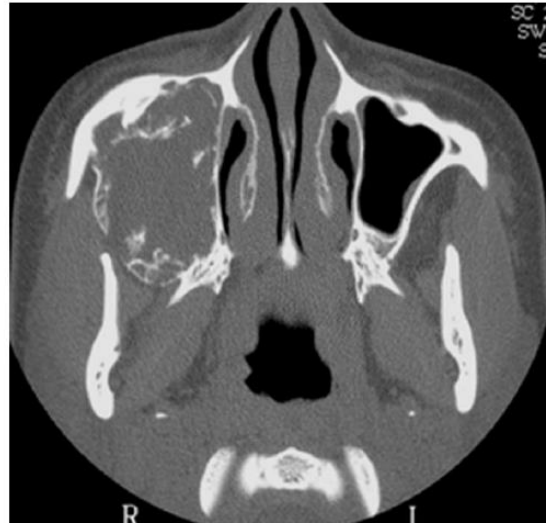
Axial CT (bone window settings) showing tumor in the right side of the maxilla. The tumor shows crevice formation on the buccal wall anteriorly and periosteal reaction on posterior border of tumor.
